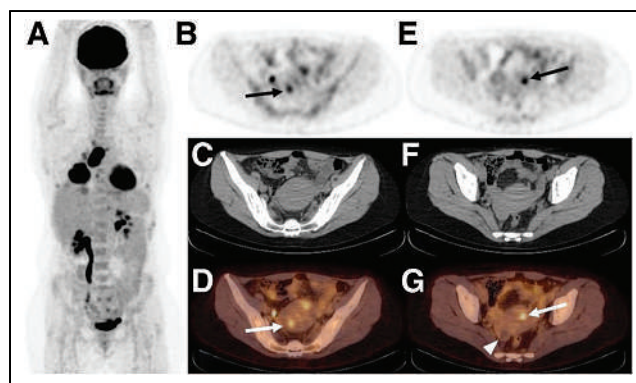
[¹⁸F]FDG PET/CT of 47-y-old woman with sarcomatous lung cancer and 11-y history of endometriosis at time of imaging. (A) Intense [¹⁸F]FDG uptake can be seen in primary lung cancer lesions as well as lymph node and pleural metastases. (B–G) Two foci of increased [¹⁸F]FDG avidity can be seen in endometriosis lesions in uterine wall via PET (B and E) and PET/CT (D and G) (arrows) but are not clearly visualized by CT alone (C and F). No [¹⁸F]FDG uptake was observed in known right ovarian endometrioma (arrowhead). (Reprinted with permission of (17).)
